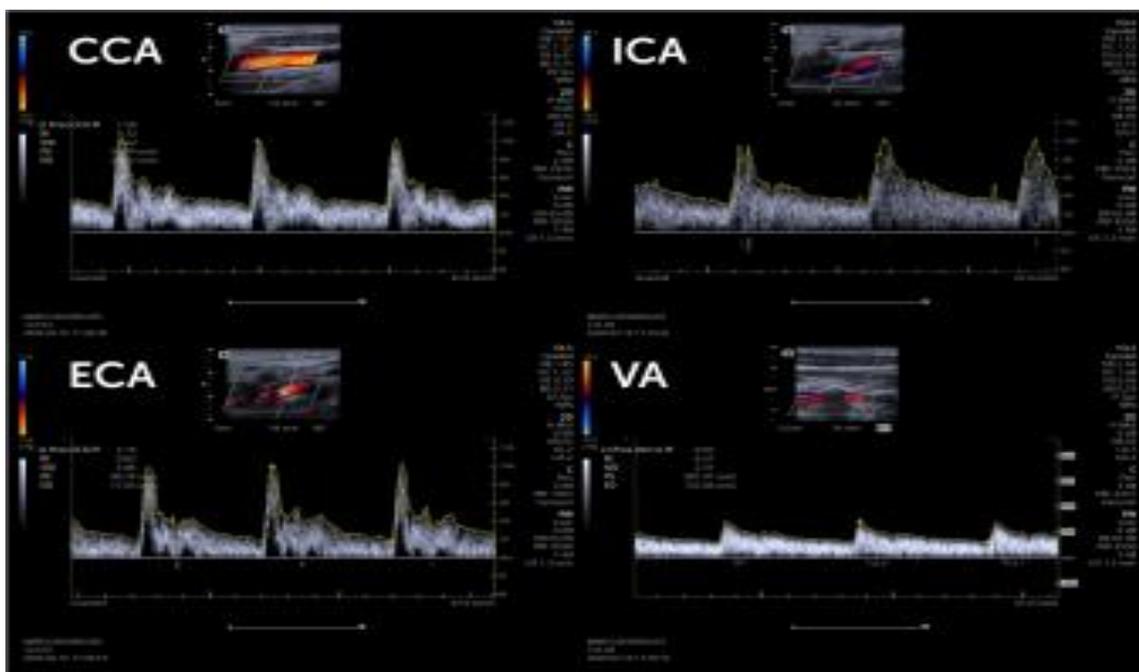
Normal Carotid Ultrasound Examination. (A) Common carotid artery. (B) Internal carotid artery. (C) External carotid artery. (D) Vertebral artery. (40).
